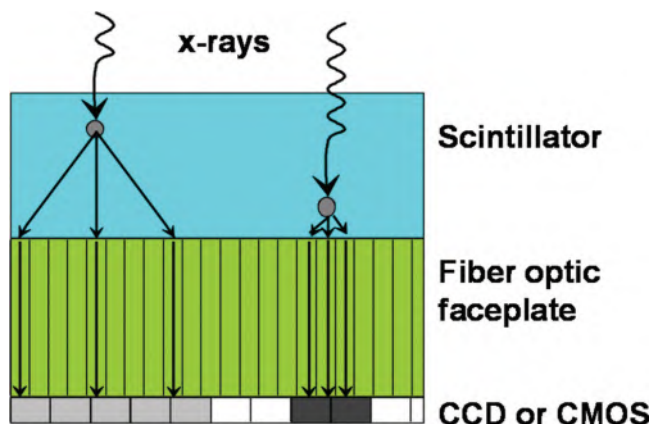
3 Indirect solid-state X-ray sensor using a scintillator to convert X-rays to light photons. The image represents a small section of such a sensor.
